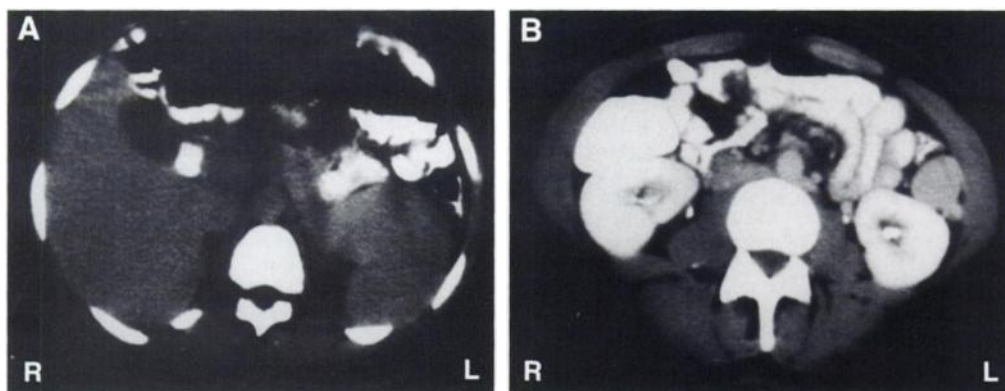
Selected slices of abdominal CT scan. (A) Note the widened and distorted lower pole of the spleen mimicking the space-occupying lesion. (B) More caudal slices showed an elongated structure adjacent to the lateral abdominal wall and the anterior surface of the left kidney.
